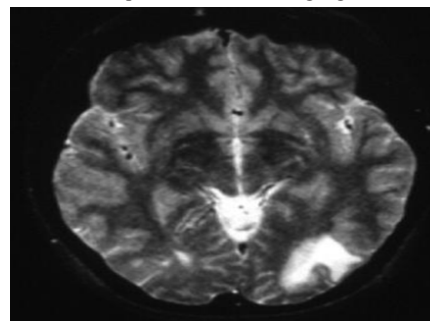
T2-weighted MRI shows left occipital hyperintense white matter changes with the lesion margin reaching the cortex.
